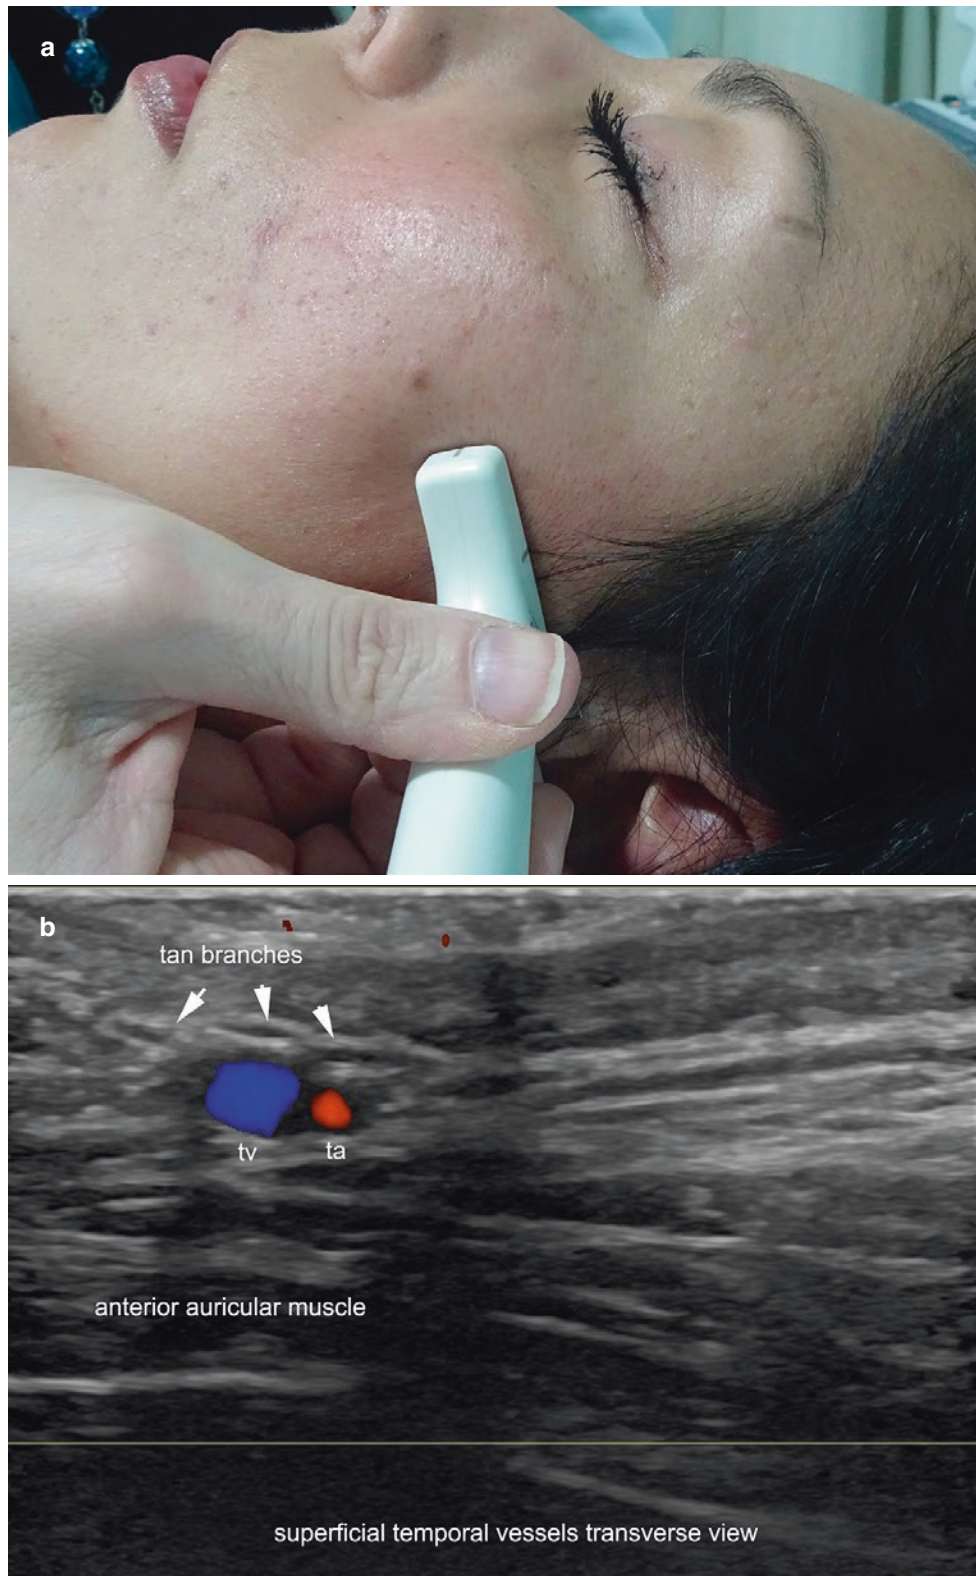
Superficial temporal vessels. (a) Clinical image shows the recommended positions of the probe for tracking the temporal vessels. (b) Color Doppler ultrasound (transverse view) demonstrates the location of the vein (tv) and artery (ta) at the preauricular region. Notice that
